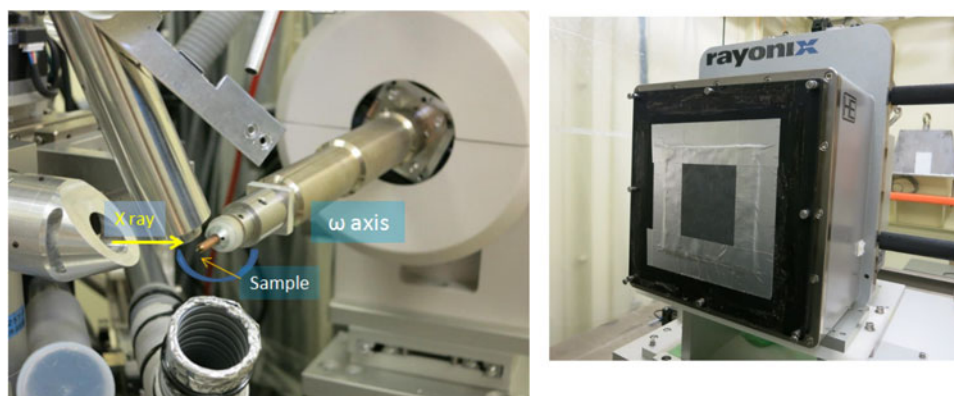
(Color online) Sample holder and goniometer (left side) and X-ray CCD detector (right side).
